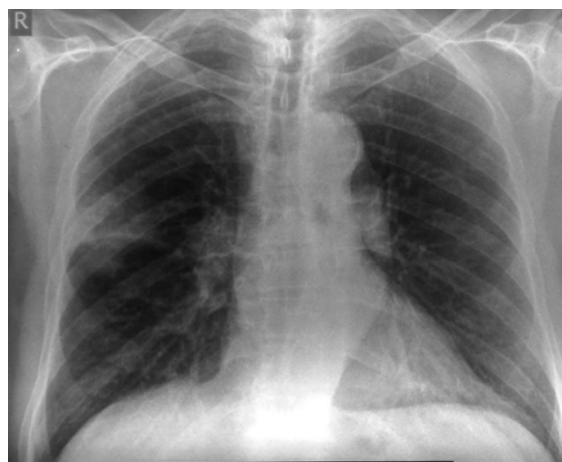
Initial chest X-ray revealed right upper lobe alveolar infiltration.
